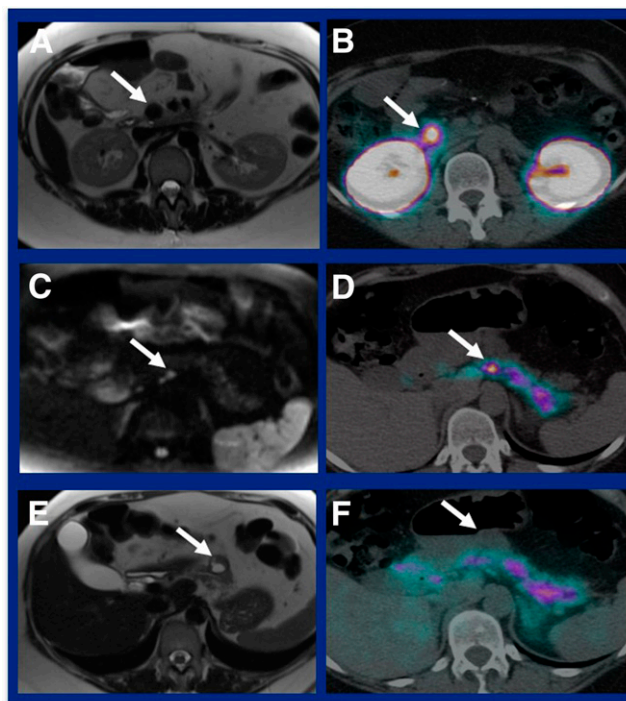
Glucagon-like peptide-1 receptor (GLP-1R) imaging in 3 patients with multiple endocrine neoplasia type 1 (MEN-1). MR (A) and MR plus ^{68}Ga -exendin-4 PET (B) showed an insulinoma ≥ 2 cm. (D) MR plus ^{68}Ga -exendin-4 PET showed an insulinoma < 2 cm that was missed on MR alone (C). (F) MR plus ^{68}Ga -exendin-4 PET showed a nonfunctional neuroendocrine tumor that was indeterminate on MR (E). GLP-1R PET/CT may not only selectively identify insulinomas among multiple pancreatic neuroendocrine tumors in patients with MEN-1 but, in combination with MR, has the potential to guide surgical procedures and avoid unnecessary pancreatic resections.
